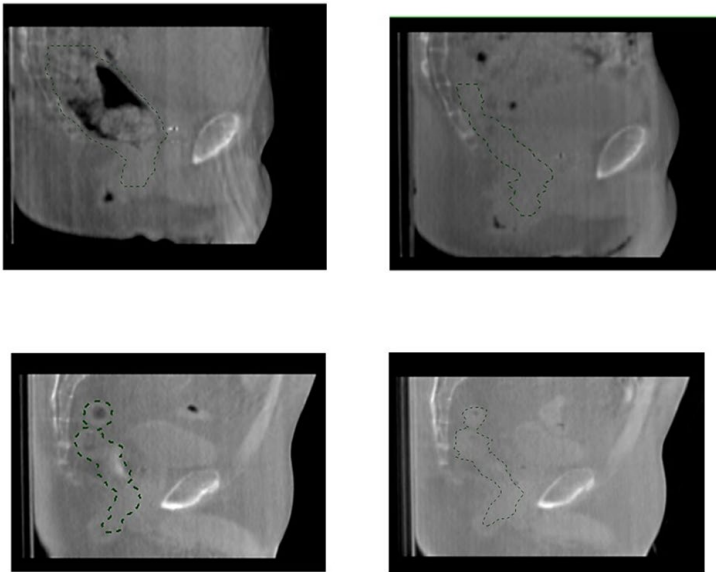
Images for the patients with the largest (above line) and smallest (below line) range on CBCT 1-8 (range 202.1 cm³ and 20.3 cm³, respectively). Green line represents outlined rectal volume. Left images represent CBCT 1 (volumes 263.9 cm³ and 87.7 cm³, respectively), right images represent CBCT 6 (61.8 cm³) and CBCT 3 (67.4 cm³), respectively.
